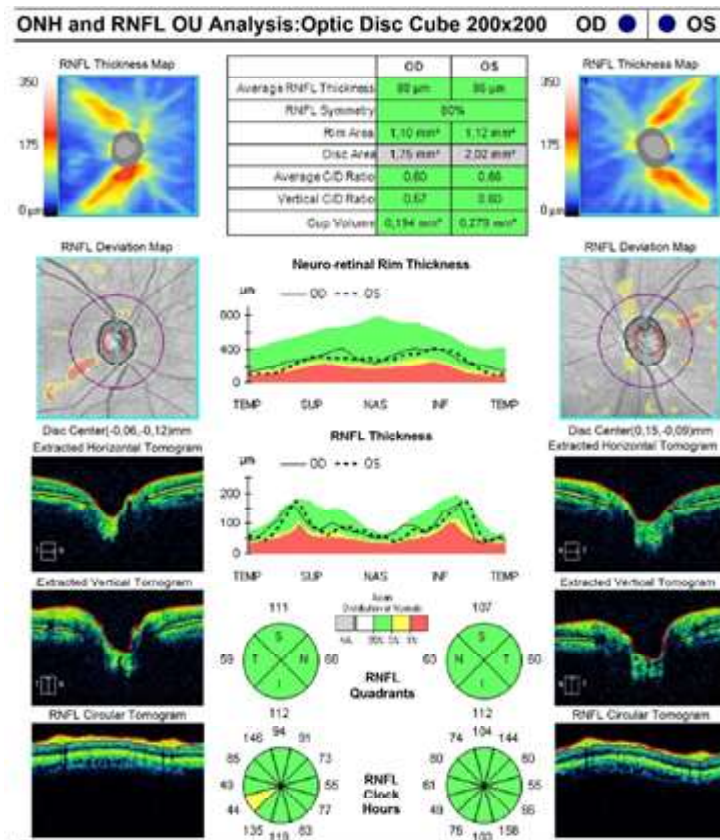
Initial ocular computed tomography (OCT) showed no significant loss of retinal nerve fiber layer (RNFL)
